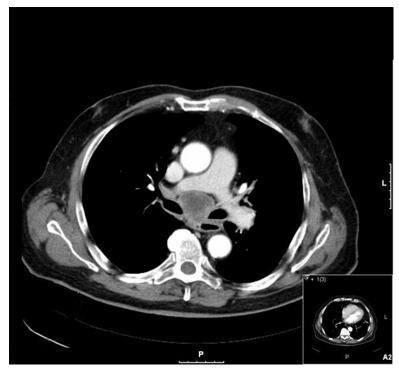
Computed tomographic scan at the same area after antibiotic treatment.
